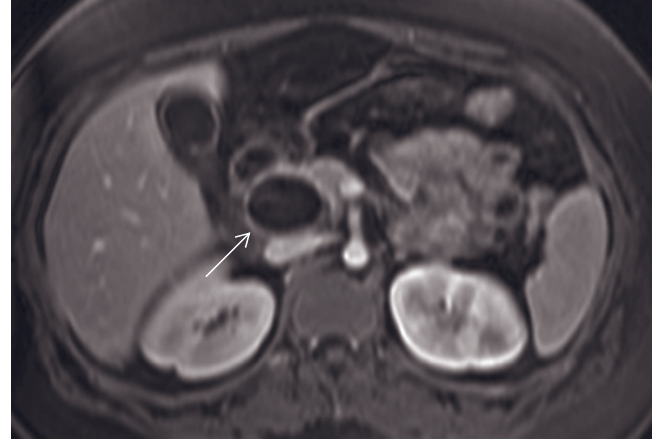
Choledochal cyst. Coronal T2-weighted single-shot echo-train spin-echo image (a) showing a high-grade cylindrical dilatation of the CHD and CBD. The intrahepatic bile ducts are normal.
